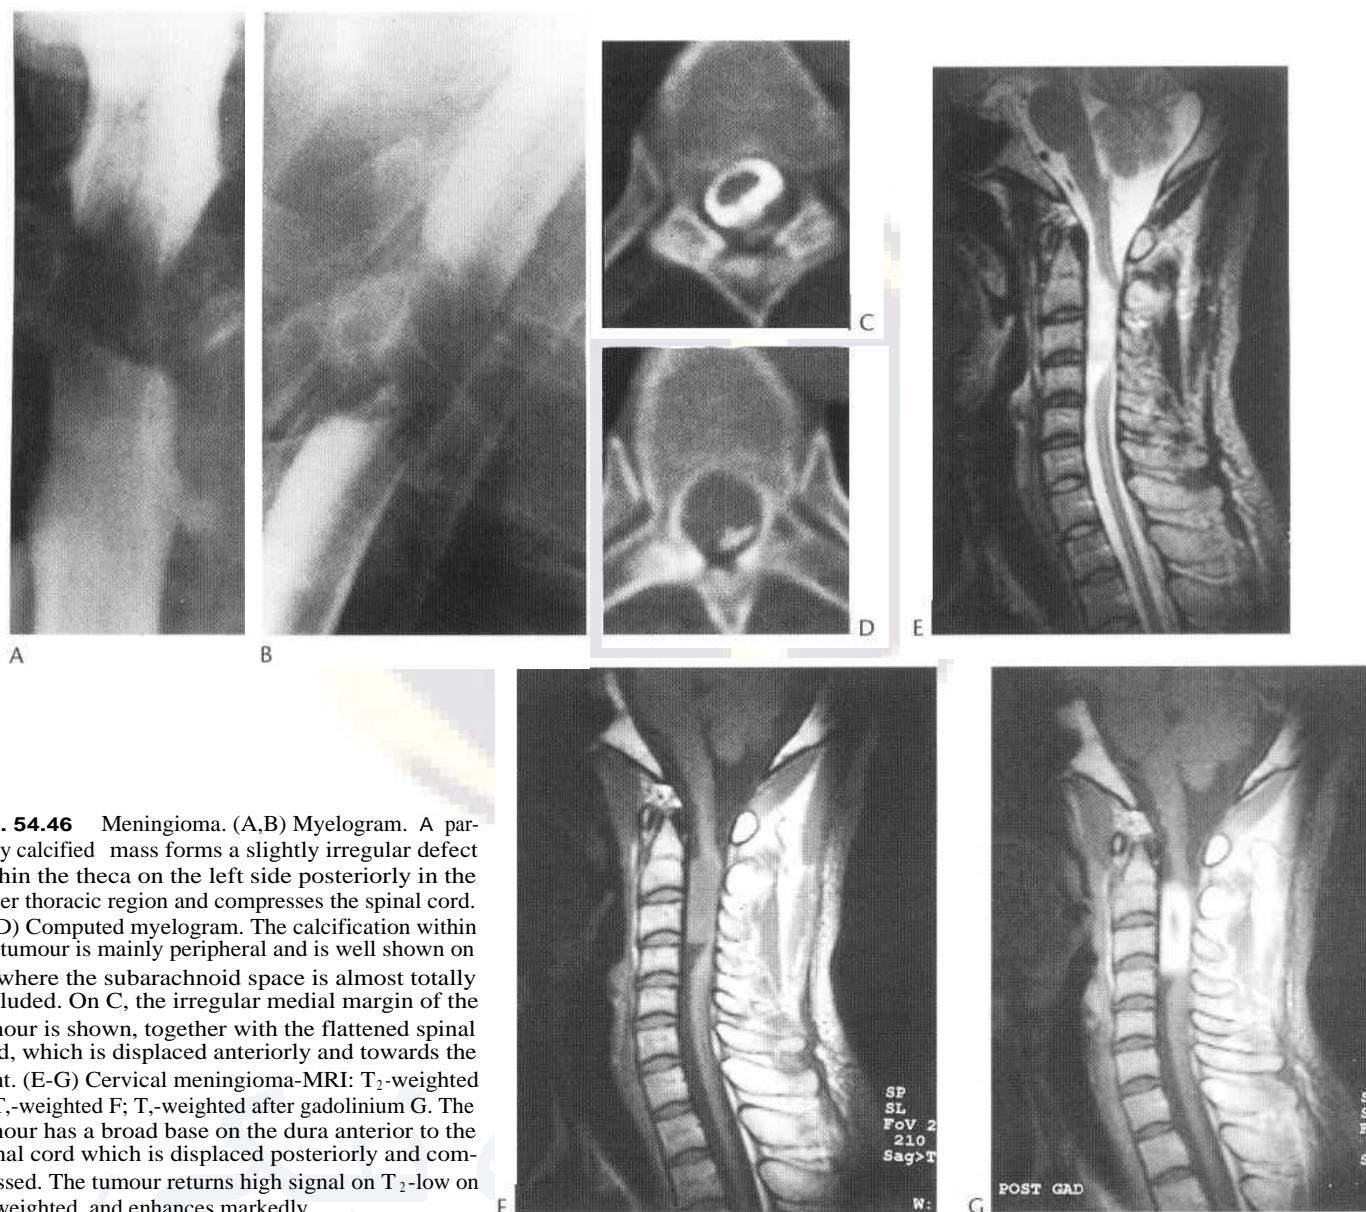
Meningioma. (A,B) Myelogram. A partially calcified mass forms a slightly irregular defect within the theca on the left side posteriorly in the upper thoracic region and compresses the spinal cord. (C,D) Computed myelogram. The calcification within the tumour is mainly peripheral and is well shown on D, where the subarachnoid space is almost totally occluded. On C, the irregular medial margin of the tumour is shown, together with the flattened spinal cord, which is displaced anteriorly and towards the right. (E-G) Cervical meningeoma-MRI: T₂-weighted E; T₁-weighted F; T₁-weighted after gadolinium G. The tumour has a broad base on the dura anterior to the spinal cord which is displaced posteriorly and compressed. The tumour returns high signal on T₂-low on T₁-weighted, and enhances markedly.
